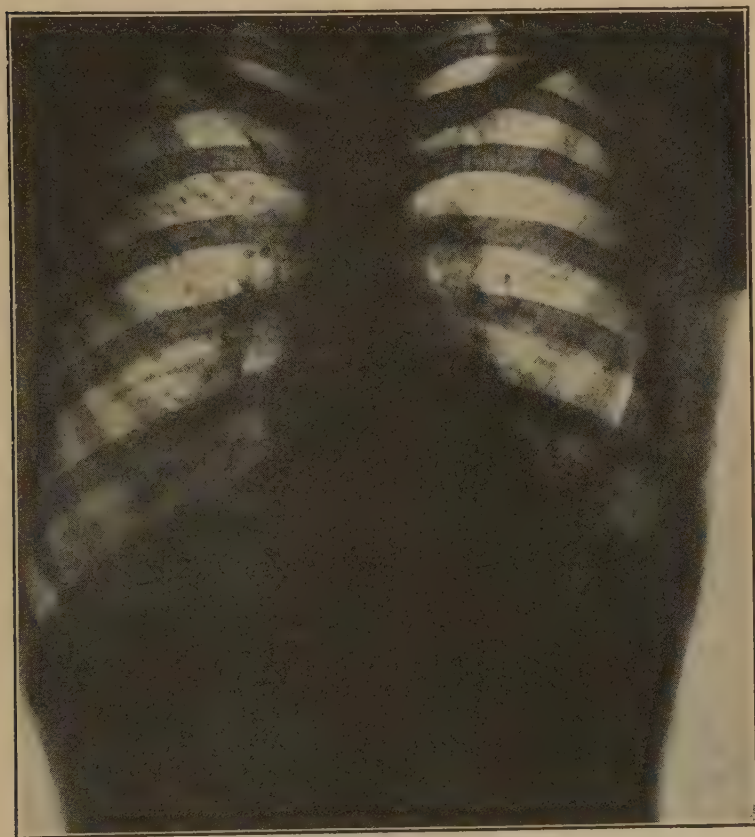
X-ray of chest, showing heavy bones.
